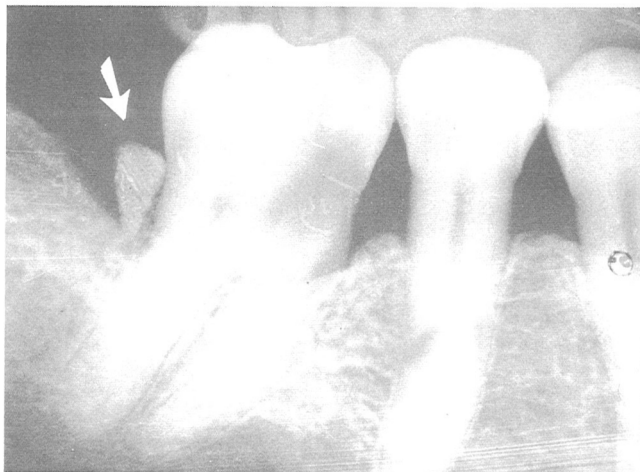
Radiograph of Case 2 at time of placement of Interpore 200 implant. The implant overfills coronal portion of the defect.
